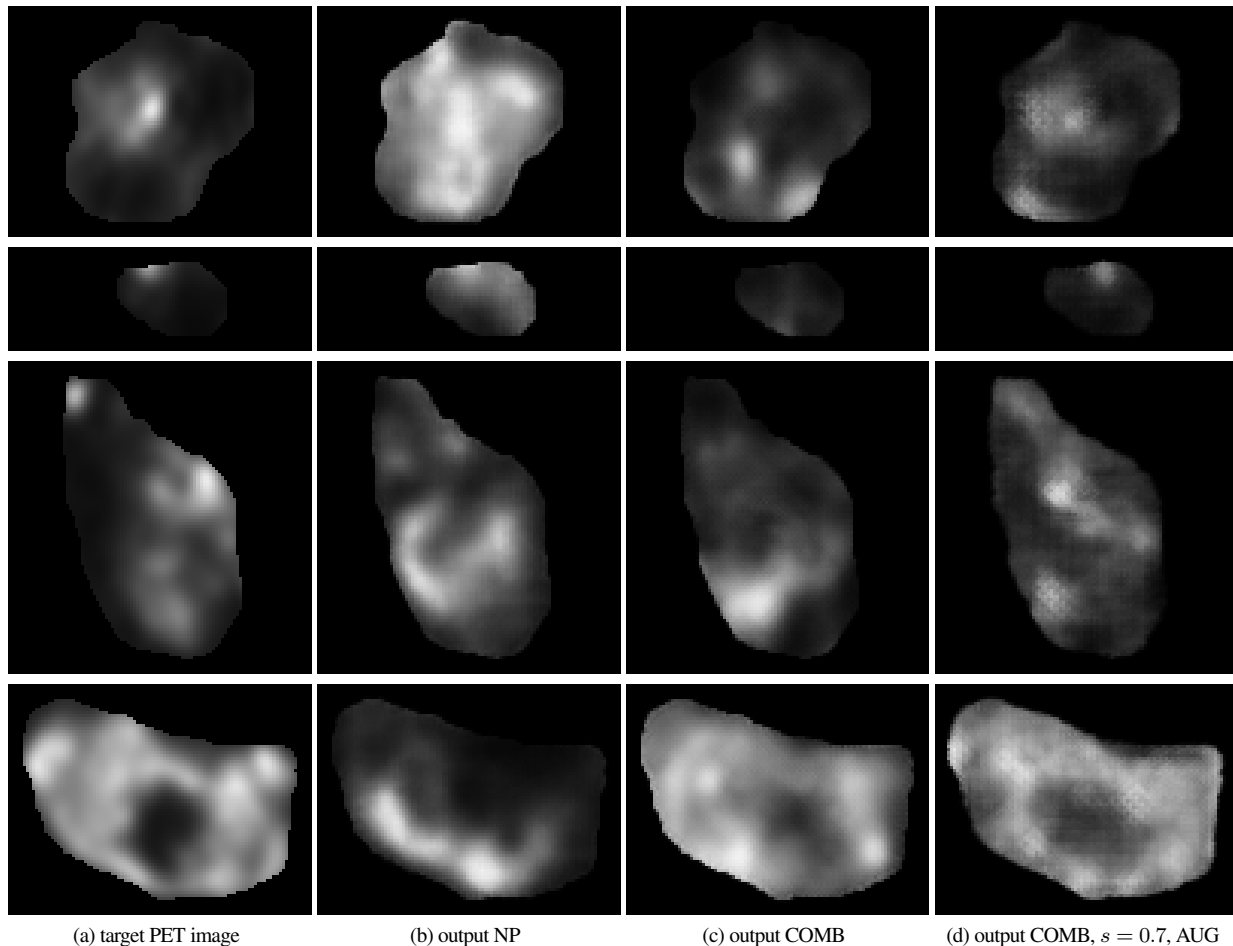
Examples of images the GAN was able to generate well from the CT images. The far left column shows the target PET image (a), the middle columns the output for training without first applying preprocessing (b) and with the most successful combination of all proposed preprocessing steps (c). In the column on the far right, the results for augmented training data with all preprocessing with a similarity over  $s = 0.7$  are shown (d).
